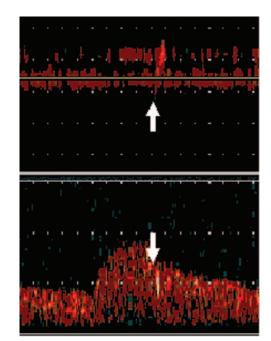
Microembolic signal on transcranial Doppler. (A) M-mode recording; the arrow points to an image of a microembolus; (B) the Doppler velocity envelope; the arrow points to the high-intensity transit signal created by the microembolus.
